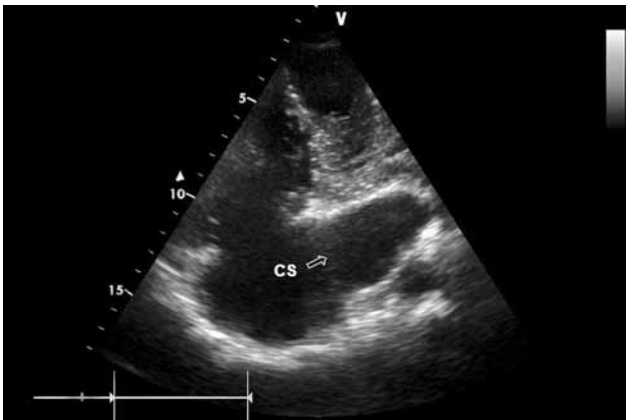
Echocardiogram showing the dilated coronary sinus (CS).
